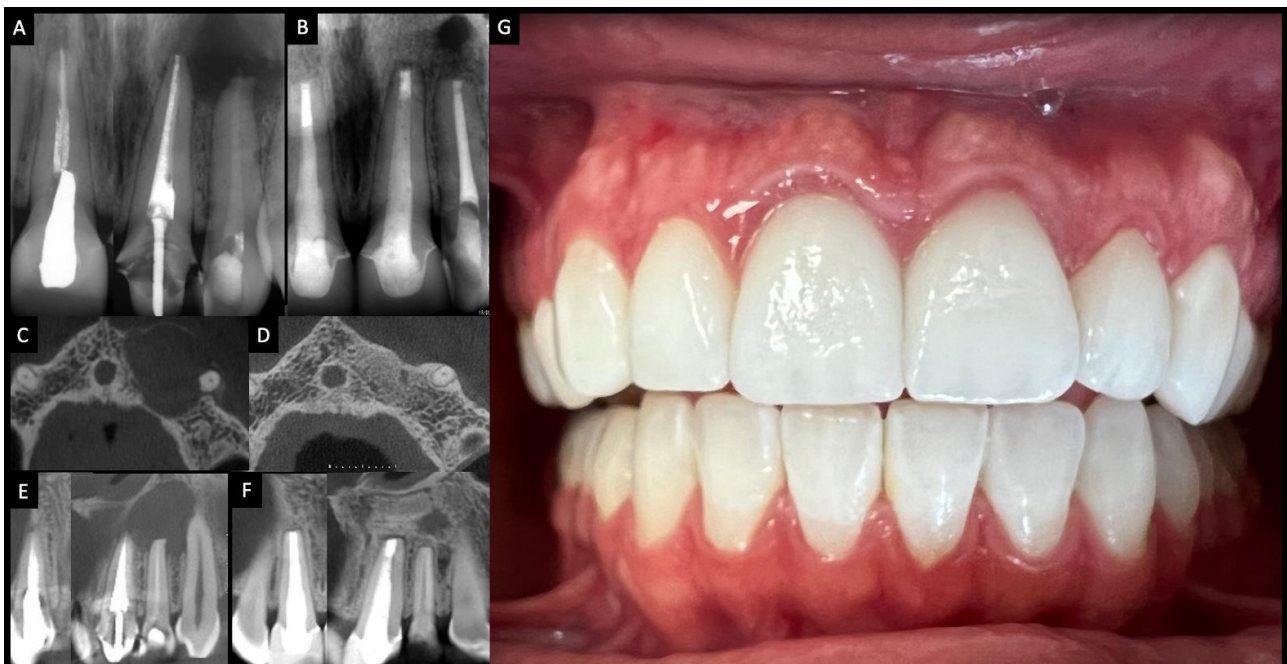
Periapical radiographs and CBCT scans (axial [C and D] and coronal [E and F] sections) before (A, C and E) and 2 years after (B, D and F) treatment, with evidence of bone repair (teeth 11 and 21) and fibrosclarring (tooth 22). Clinical aspect of gingival health (G).
